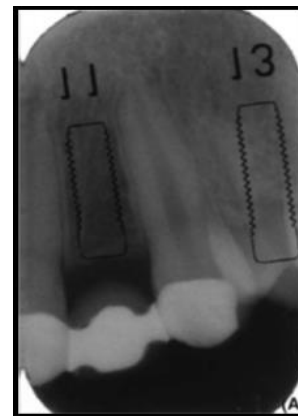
An intraoral radiograph of a maxillary lateral incisor space with an overlay showing an 11-mm-long _ 3.5-mm-diameter implant allowing an assessment of distance between the implant surface and adjacent tooth root.
